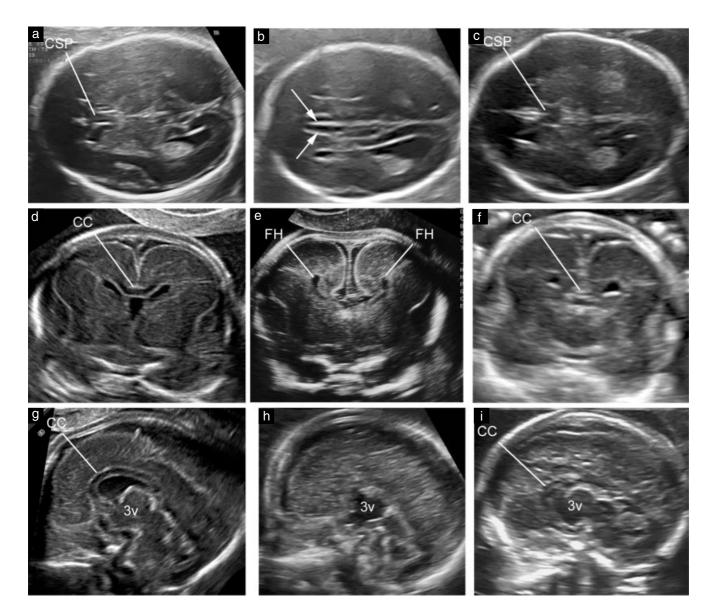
Sonography of a normal fetal brain (a,d,g) and fetal brains showing complete (b,e,h) and partial (c,f,i) callosal agenesis in axial (a-c), coronal (d-f) and mid-sagittal (g,h,i) views of the head in the second trimester of gestation. In complete agenesis, the anatomical complex formed by corpus callosum (CC) and cavum septi pellucidi (CSP) is completely absent, the interhemispheric fissure is enlarged (arrows), and the frontal horns (FH) are more widely separated than normal. In partial agenesis, the findings are more subtle, and the CC and CSP are present but shortened. 3v, third ventricle.
